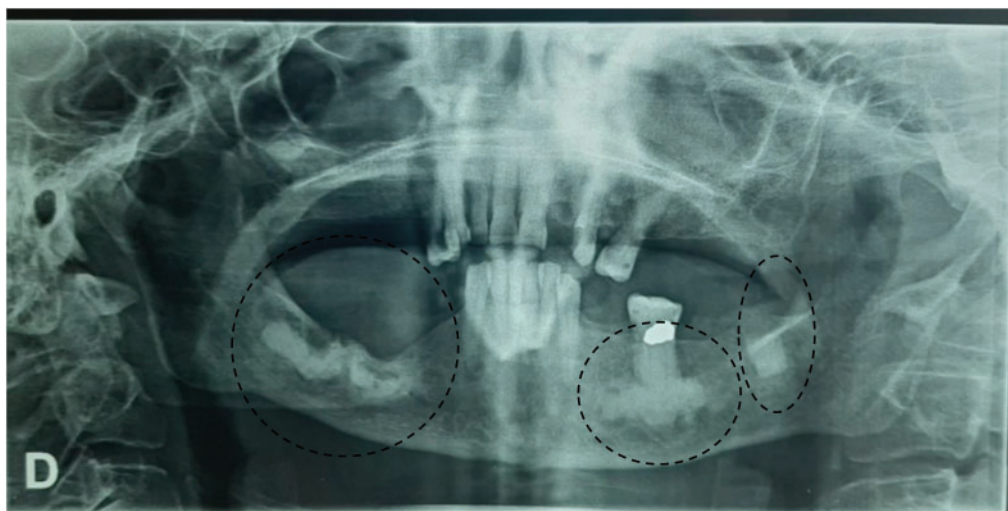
The panoramic radiography revealed a posterior right mandibular radiopacity, a radiopacity on the periapical area of tooth 36 and another left mandibular radiopacity.
